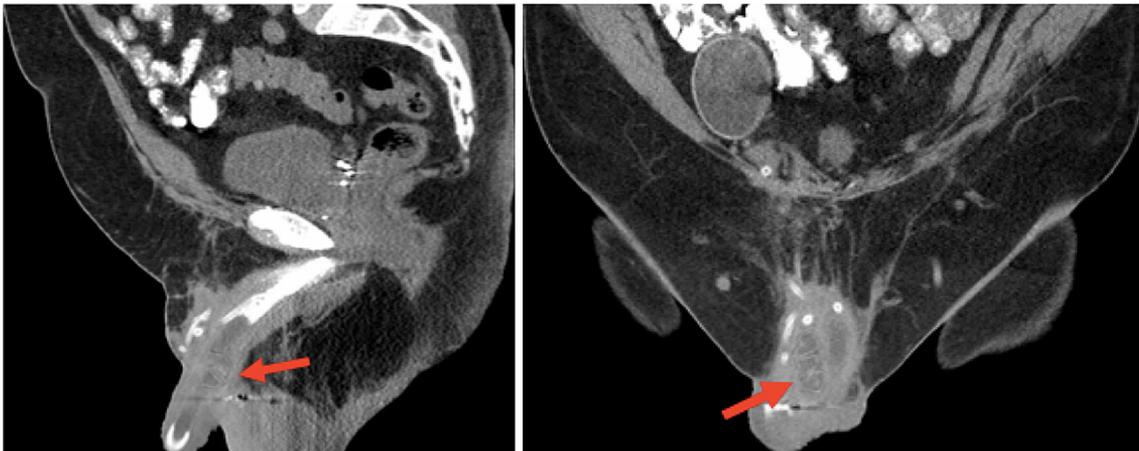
Coronal CT image shows an aneurysm (red arrow) of the proximal right cylinder.
